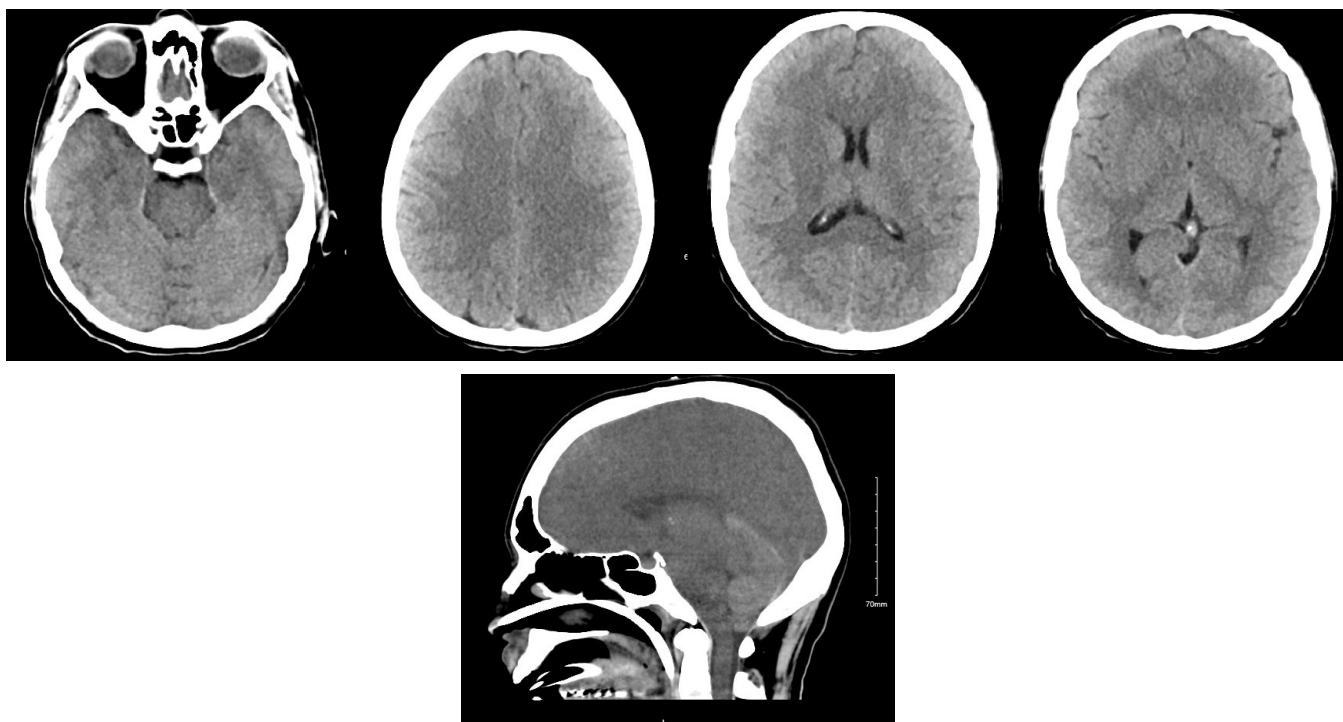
Non-contrast brain CT showing progressive worsening in cerebral edema with disappearance of cistern and brain herniation in the sagittal section.
